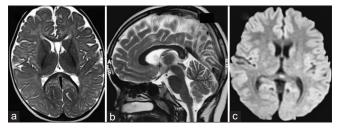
Reversible splenial lesion syndrome (RESLES): Axial (a) and sagittal (b) T2 images show focal, well-defined hyper-intensity in splenium; the same area shows diffusion restriction on DWI image (c). Abbreviations: AED: antiepileptics, AESD: acute encephalopathy with biphasic seizures and delayed reduced diffusion, ANE: acute necrotizing encephalopathy of childhood, DBS: deep brain stimulation, ECT: electroconvulsive therapy, FIRES: fever infection-related epilepsy syndrome, IHHE: infantile hemiconvulsion hemiplegia epilepsy syndrome, IvIG: intravenous immunoglobulin, KD: ketogenic diet
